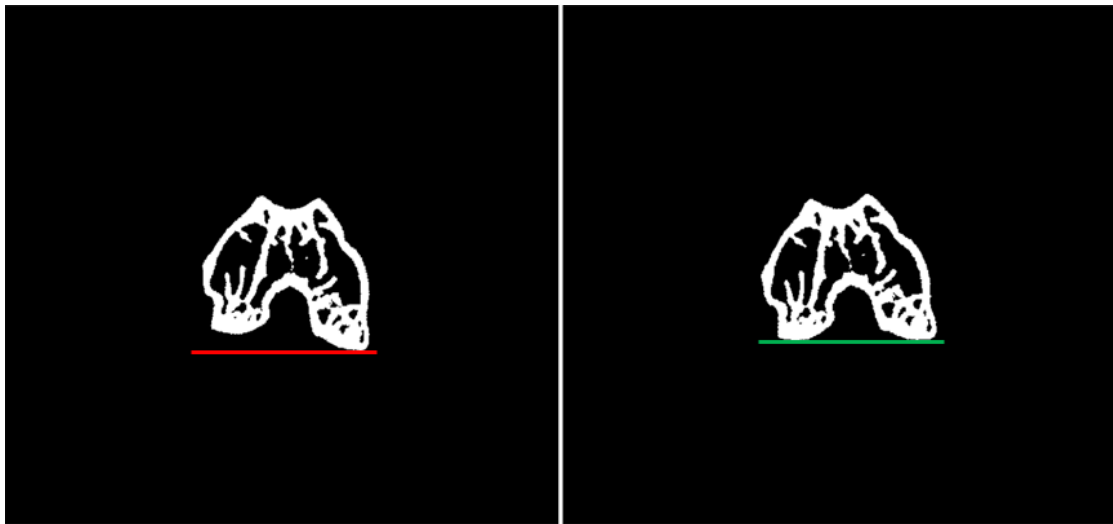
Fine tuning the alignment of the condyles with the horizontal axis of the CT images.
